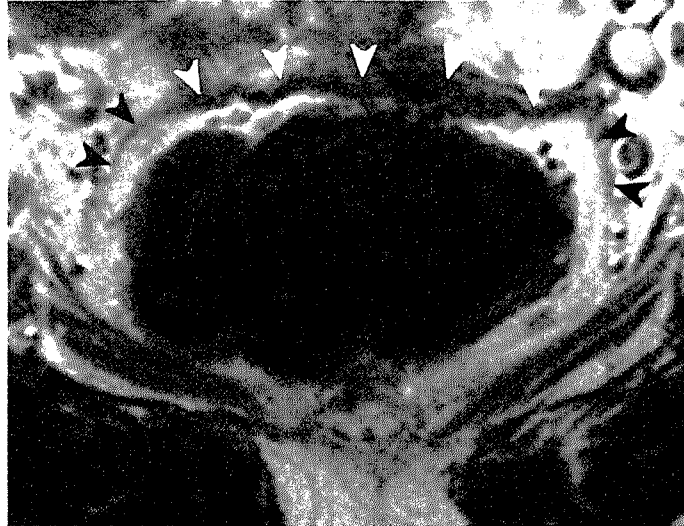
Axial T2W FSE (TR/TE 5312/150 msec) MR image of a healthy female volunteer shows the mesorectal fascia (black arrowheads) as a fine line of low signal intensity surrounding the mesorectal fat. The Denonvilliers' fascia is also visualized (white arrowheads) posterior to the vagina.
